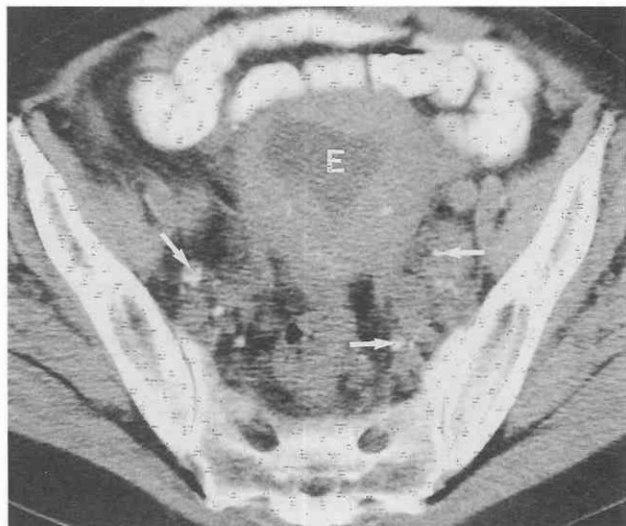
Calcified nodal metastases. CT scan through the uterus shows a distended endometrial cavity (E) and multiple nodal metastases (arrows) from a papillary serous adenocarcinoma of the endometrium.
